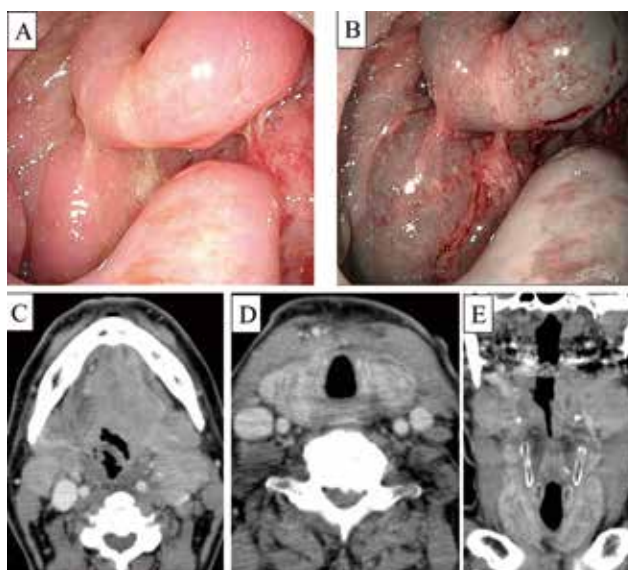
(A) White light and (B) narrow-band endoscopy images as well as (C) axial oropharyngeal, (D) axial thyroid, and (E) coronal thyroid enhanced computed tomography images in oropharyngeal cancer.
